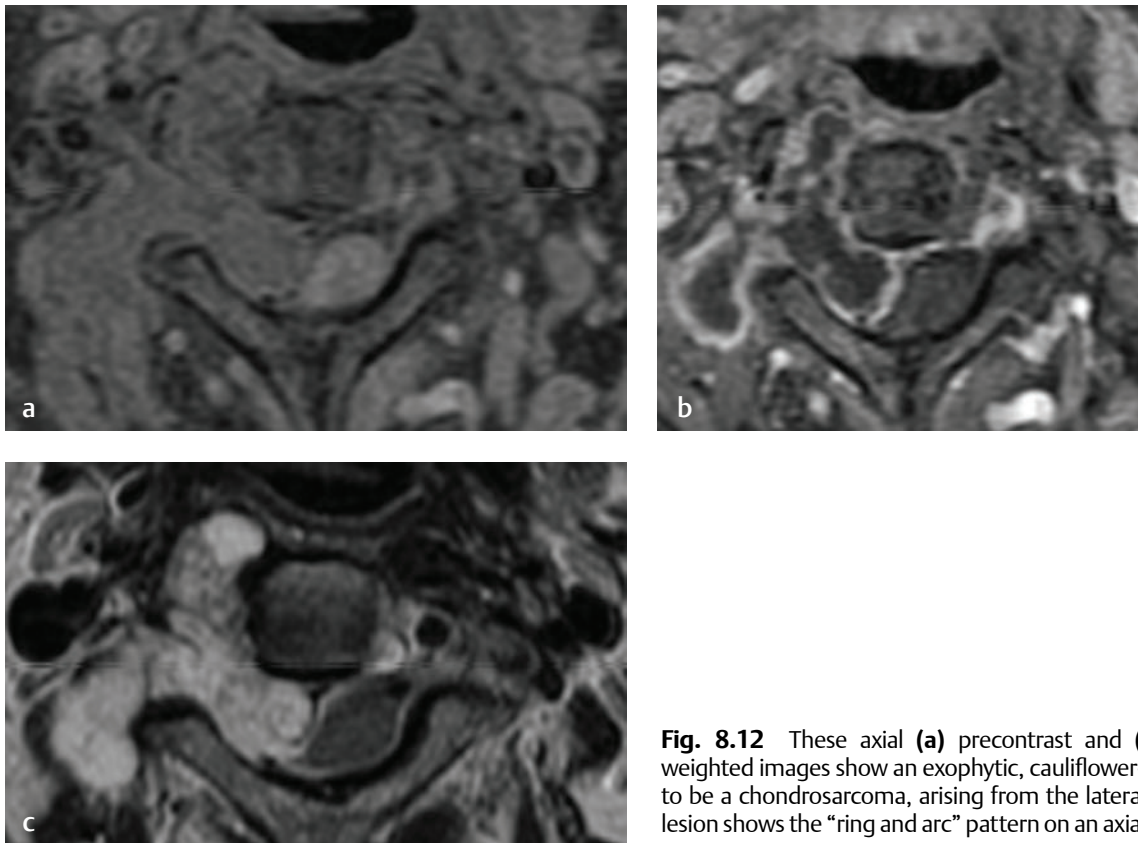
These axial (a) precontrast and (b) postcontrast T1-weighted images show an exophytic, cauliflower-shaped lesion, found to be a chondrosarcoma, arising from the lateral mass of C2. (c) The lesion shows the “ring and arc” pattern on an axial T2-weighted image.
